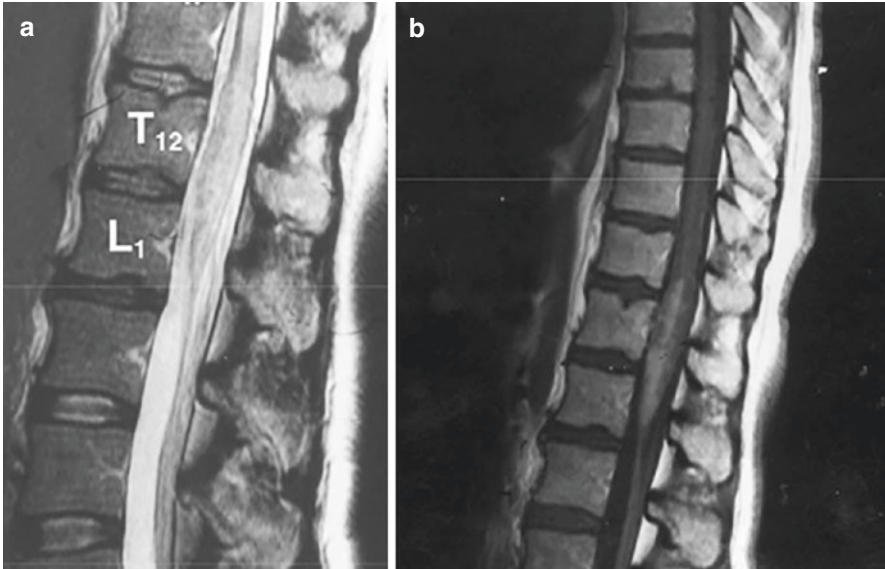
MRI Spine in a case of Schistosomiasis. Image (a) shows sagittal T2w sequences of the spine showing swelling and hyperintense signal change of the caudal spinal cord and conus medullaris. Image (b) shows postcontrast sagittal T1w sequences of the spine showing patchy avid enhancement of the caudal spinal cord and conus medullaris. There is also some caudal nerve root thickening and enhancement
